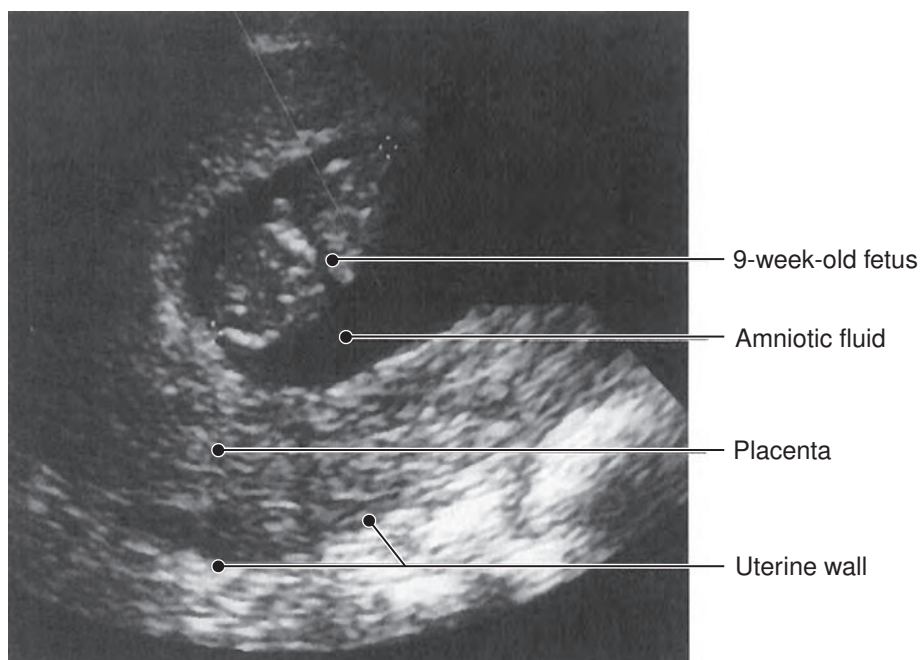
Sonogram. This transvaginal sonogram shows a 9-week-old fetus.
